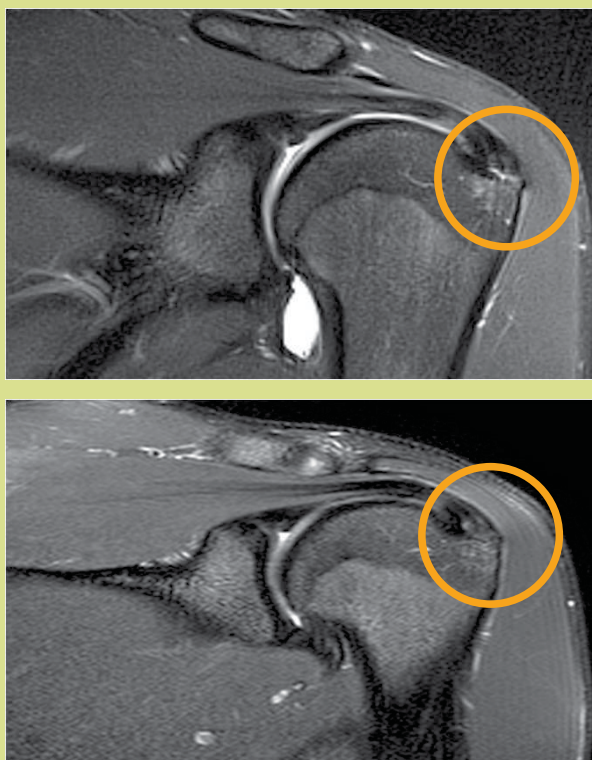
MRI Images before Ortho-ATI™ treatment and at ten months after treatment
